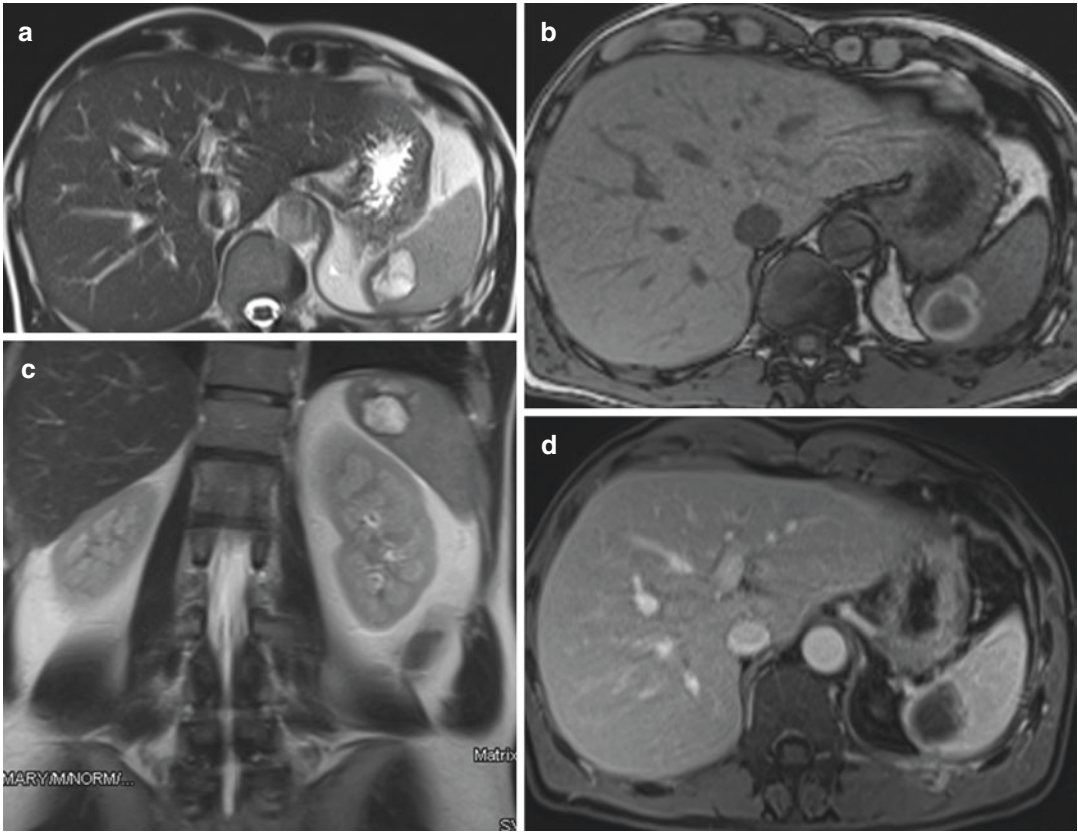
(a–d) Same patient. Follow-up with MRI after 1 month. (a, c) HASTE T_2 -weighted axial and coronal sequences. (b) T_1 out-of-phase. (d) VIBE T_1 -weighted image after contrast media administration. In the upper
